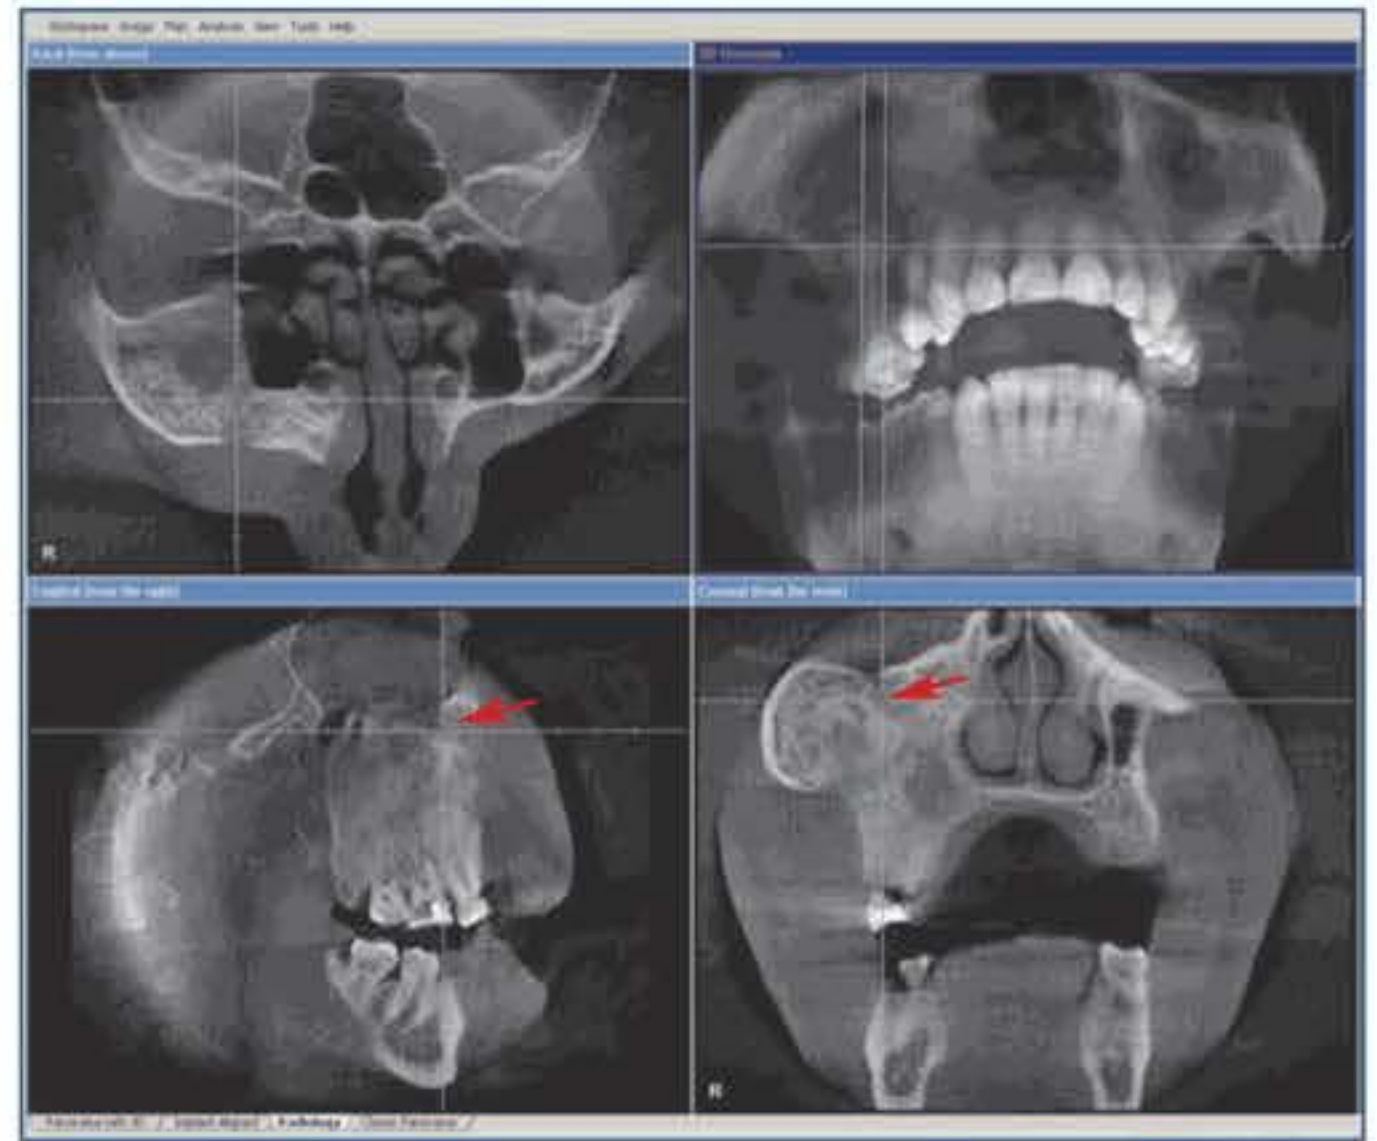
Cone-beam volumetric imaging of a 47-year-old male who presented with chronic pain in the right maxilla and slowly increasing distension of the cheek. The right maxilla and the zygomatic bone were distended and have resulted in an enclosure of the infraorbital nerve (arrow) and a reduction of the maxillary sinus. The bone structure shows both punctate osteolysis and zones of increased mineralization, which are more poorly demarcated from the surrounding tissue than in an ossifying fibroma.
